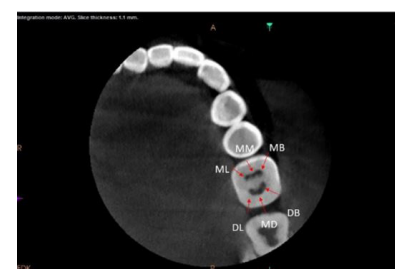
Axial CBCT image of mandibular first molar demonstrating six canals in the mesial and distal roots (ML: Mesiolingual; MM: Middle Mesial; MB: Mesiobuccal; DB: Distobuccal; MD: Middle Distal; and DL: Distolingual).
